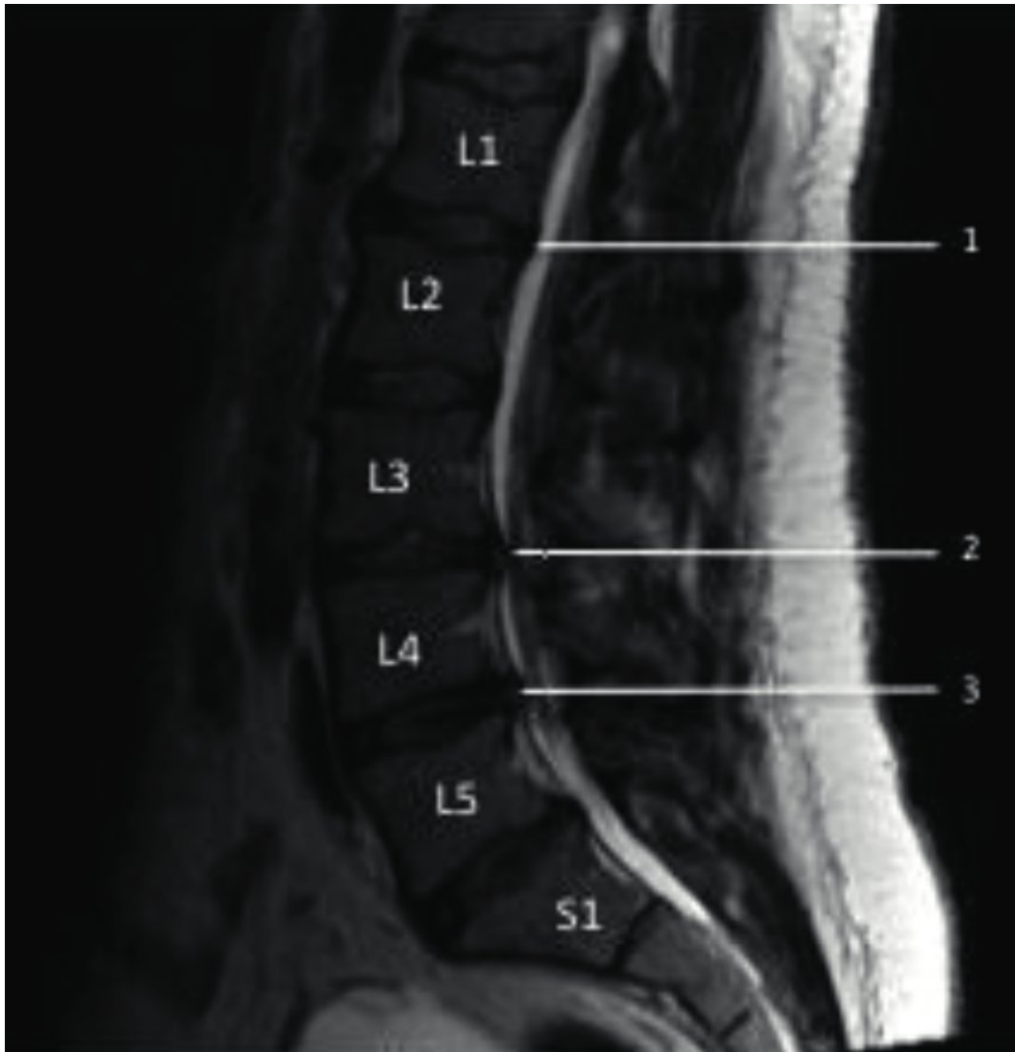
Magnetic resonance imaging (MRI) sagittal cut through the spinous process. 1, end of spinal cord (conus medullaris); 2, L3–L4 disk prolapse; 3, L4–L5 disk prolapse. MRI sagittal cut through right pedicles. 4, L1 pedicle; 5, normal L2 exiting nerve root; 6, stenosed L4 nerve root.
